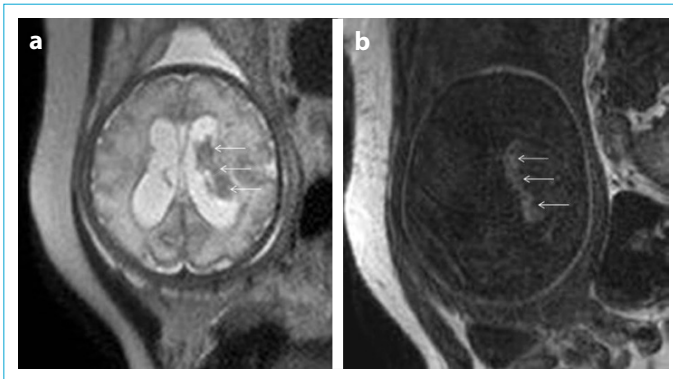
(a, b). Intraventricular hemorrhage (arrows) is seen hypointense in T2-weighted image (a), and hyperintense in T1-weighted image (b) in the left lateral ventricle.
